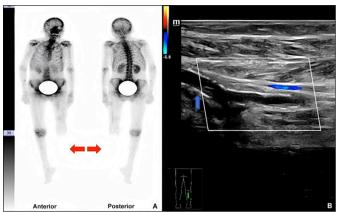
(A) Whole-body bone static imaging showing a focal cold defect (red arrow) in the distal left femur, indicating absent radiotracer uptake due to impaired perfusion. (B) Doppler ultrasound at the left knee shows complete absence of flow in the popliteal artery (blue arrow), confirming occlusion of distal left leg vessels.
